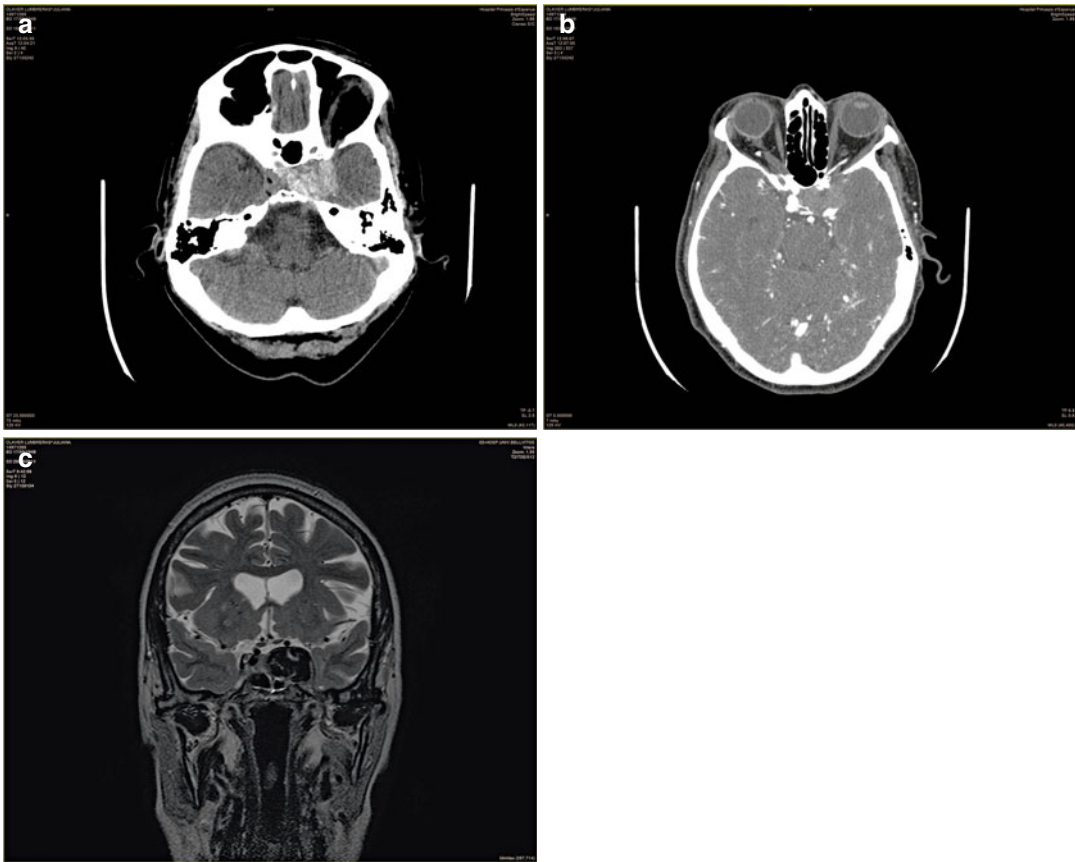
(a) CT scan shows a large round hyperdense lesion centered in the left cavernous sinus. (b) Angio-CT demonstrates a giant partially thrombosed CCA with a small area of contrast enhancement. (c) MRI identifies a
